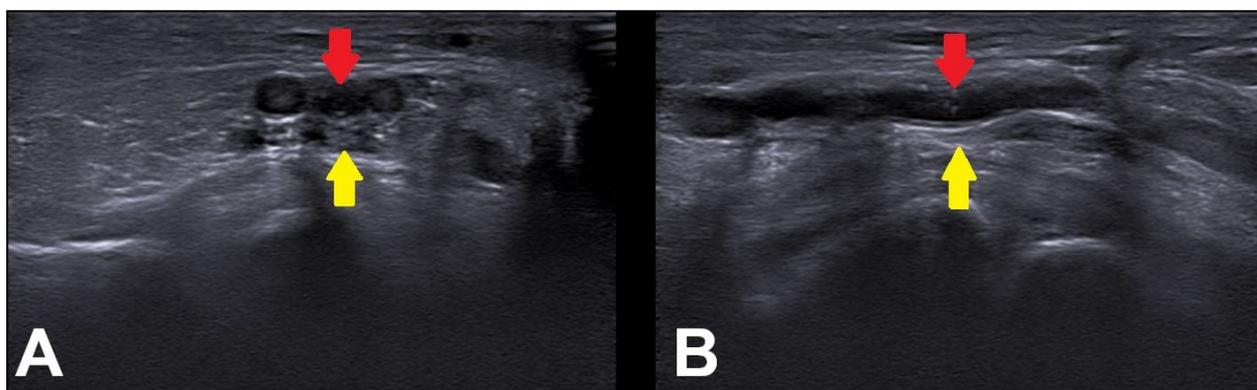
Axial (A) and longitudinal (B) ultrasound images demonstrating tortuosity of the posterior tibial artery (red arrow) in close contact with the medial plantar nerve (yellow arrow), consistent with neurovascular compression.
